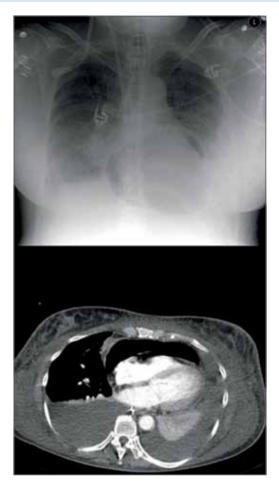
Chest radiography showing the typical appearance of pneumopericardium that was confirmed by high resolution CT.
